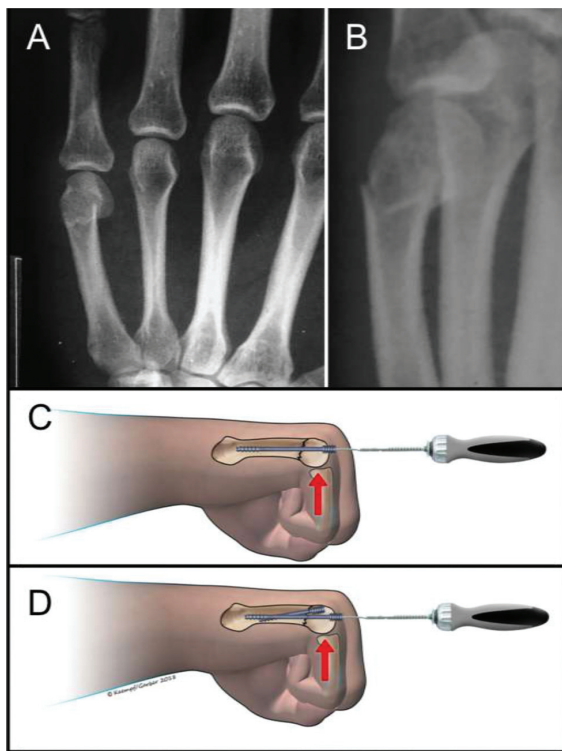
Percutaneous headless screws intramedullary fixation technique. (A) Radiographic features—Boxer’s fracture (B) Radioscopic features—Boxer’s fracture (C and D) Headless screws retrograde intramedullary insertion.
